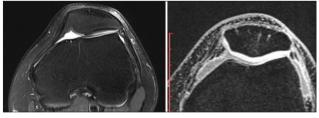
Preoperative and postoperative magnetic resonance imaging examination comparison chart. Axial patellar osteophytes were cleared, and the joint space increased.
